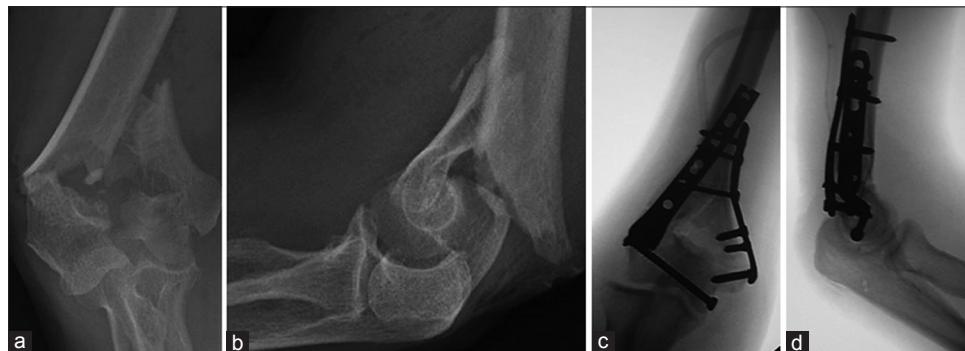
Preoperative X-ray of elbow joint (a) anteroposterior view (b) lateral view showing C2 fracture. (c) Postoperative X-ray anteroposterior view (d) lateral view showing medial and lateral plates
